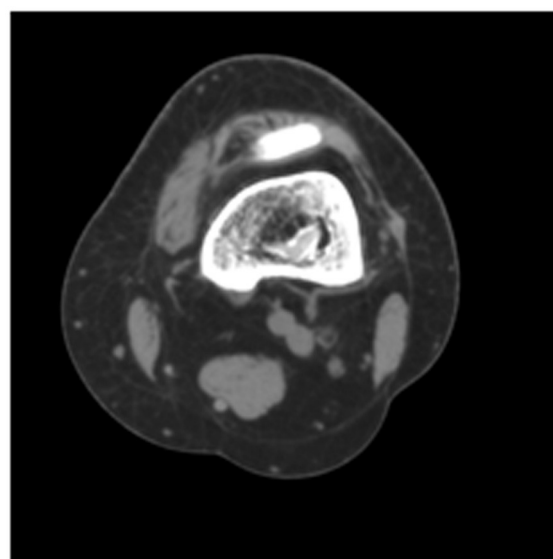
CT coronal section; right distal femur at 2 years after ACL reconstruction with autologous ligament: the sclerotic margin of containment and the preservation of bone density are a valid support for the neo ligament anchorage
